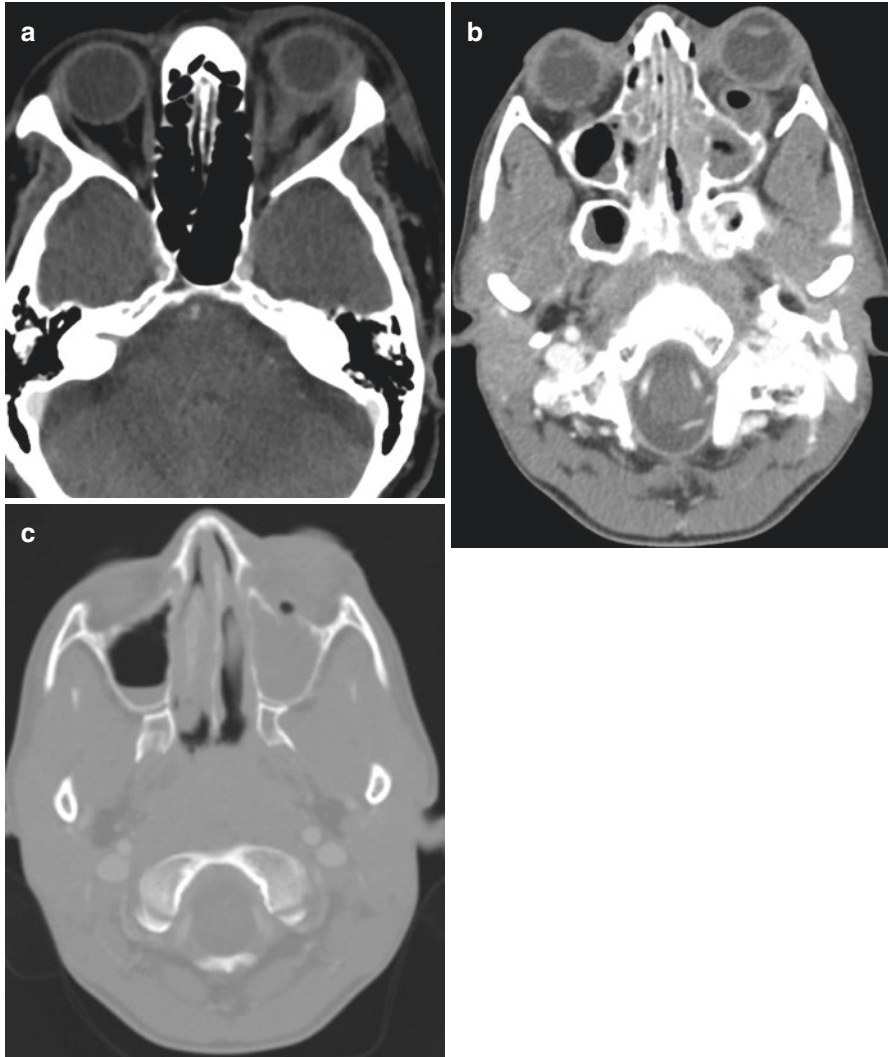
Contrast-enhanced axial orbital CT (a) shows left intraconal and retrobulbar fat infiltration by a soft tissue density lesion representing orbital cellulitis and phlegmon in a patient, who has preseptal cellulitis. Axial postcontrast soft tissue images (b) of the orbit of a different patient exhibits a retrobulbar abscess and in bone window (c) reveals the cause of the abscess as left maxillary sinusitis
